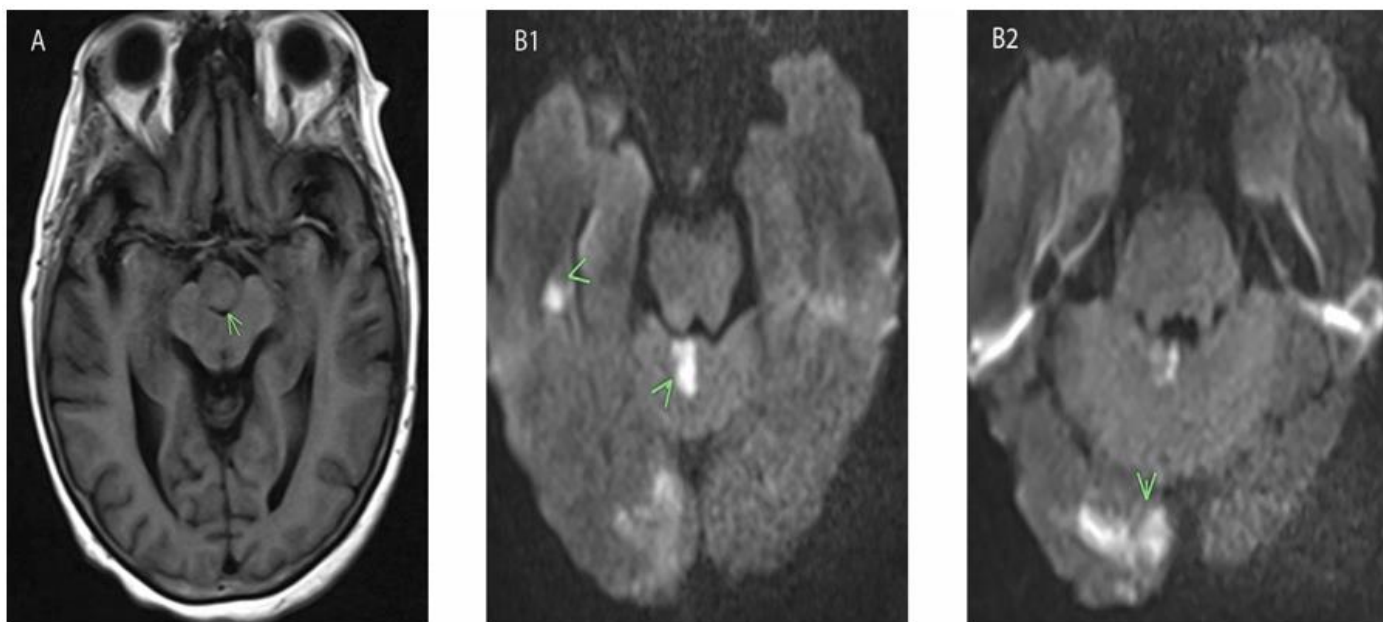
MRI scan. A. T1 sequence. Thrombosed aneurysm (arrow). B. Trace sequence. Evidence of acute ischemia in the right temporal lobe and cerebellum (B1) and occipital lobe (B2) (arrows).
